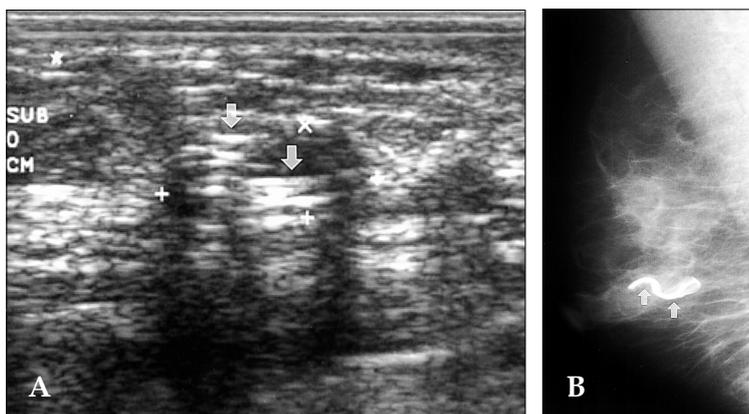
A 33-year-old woman with a prior history of breast excision due to a fibroadenoma presented with a palpable mass in the right breast. (A) Breast ultrasonogram reveals multiple, linear-arranged, echogenic lesions in the right subareolar area, suggesting a foreign body (arrows). (B) Mammography (mediolateral oblique view) shows the folded tubular shape of a high density drain tube (arrows).
